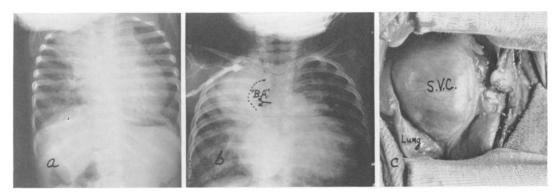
(N. C.) a. Postero-anterior roentgenogram portraying "figure-of-eight" or "snowman shadow" considered characteristic of total anomalous pulmonary venous drainage. Unusual amount of shadow seen in right upper paramediastinal area was produced by massive aneurysmal changes in superior vena cava. b. Venous angiogram revealing huge aneurysm of superior vena cava area. "B.A." ("blackout" or "washout area") demonstrates region of decreased concentration of contrast media produced by inflow of pulmonary venous blood through orifice of left innominate vein. c. Photograph taken at time of thoracotomy showing large, thin-walled aneurysm of superior vena cava (S.V.C.) compressing adjacent lung tissue.
